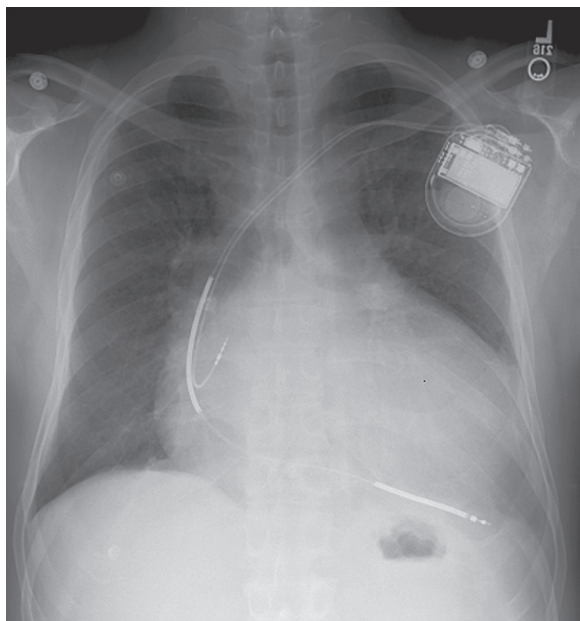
■ Posteroanterior chest radiograph showing appropriate lead positions for a dual-chamber transvenous implantable cardioverter-defibrillator.
